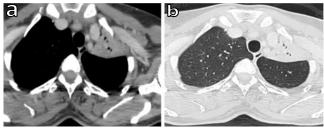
Thoracic CT scan in mediastinal and parenchymal windows showing a left upper lobar tumor mass
